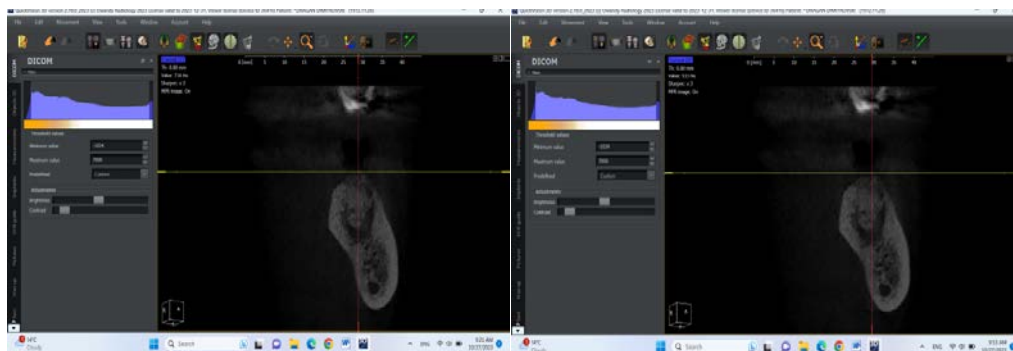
CBCT bone density-socket Figure 9. CBCT bone density- periapical
